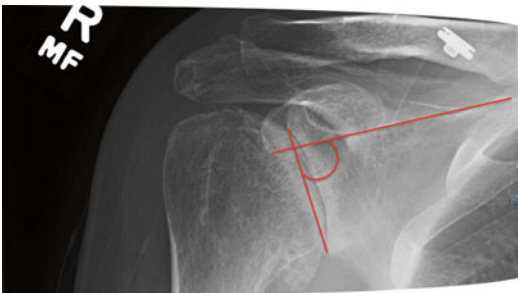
Glenoid inclination* – glenoid inclination can be measured by the angle between the glenoid fossa line (vertical line) and a horizontal scapular reference. This can be measured on radiographs as well as CT reconstructed images. Maur et al. found the angle between the glenoid fossa line (line from the superior to inferior tip of the glenoid) and the floor of the supraspinatus fossa was most reliable at measuring glenoid inclination [42]
